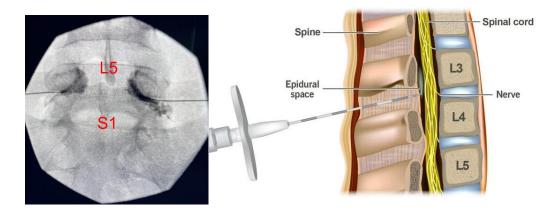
X-ray Image of Epidural Steroid Injection process on Low Back Pain (*Epidural: What It Is, Procedure, Risks & Side Effects*, 2021).
